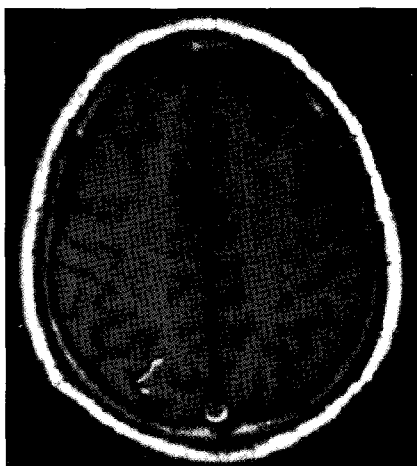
FLAIR magnetic resonance image showing high signal intensity on sensory cortex of right parietal lobe.
